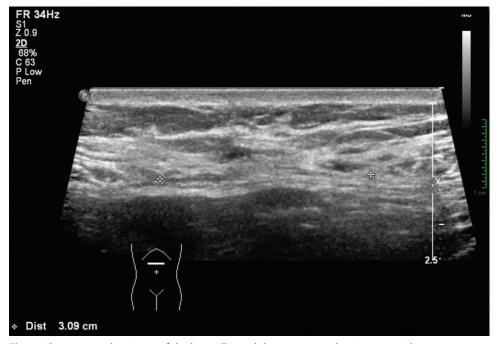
Ultrasonographic image of the linea alba and the rectus muscles in a man with pectus excavatum, 31 years of age, 23.2 body mass index (patient 3). Transverse scan at the origin at the epigastric area. The + marks show the medial edges of the rectus abdominis muscles. The measured distance between the edges was 3.09 cm.
